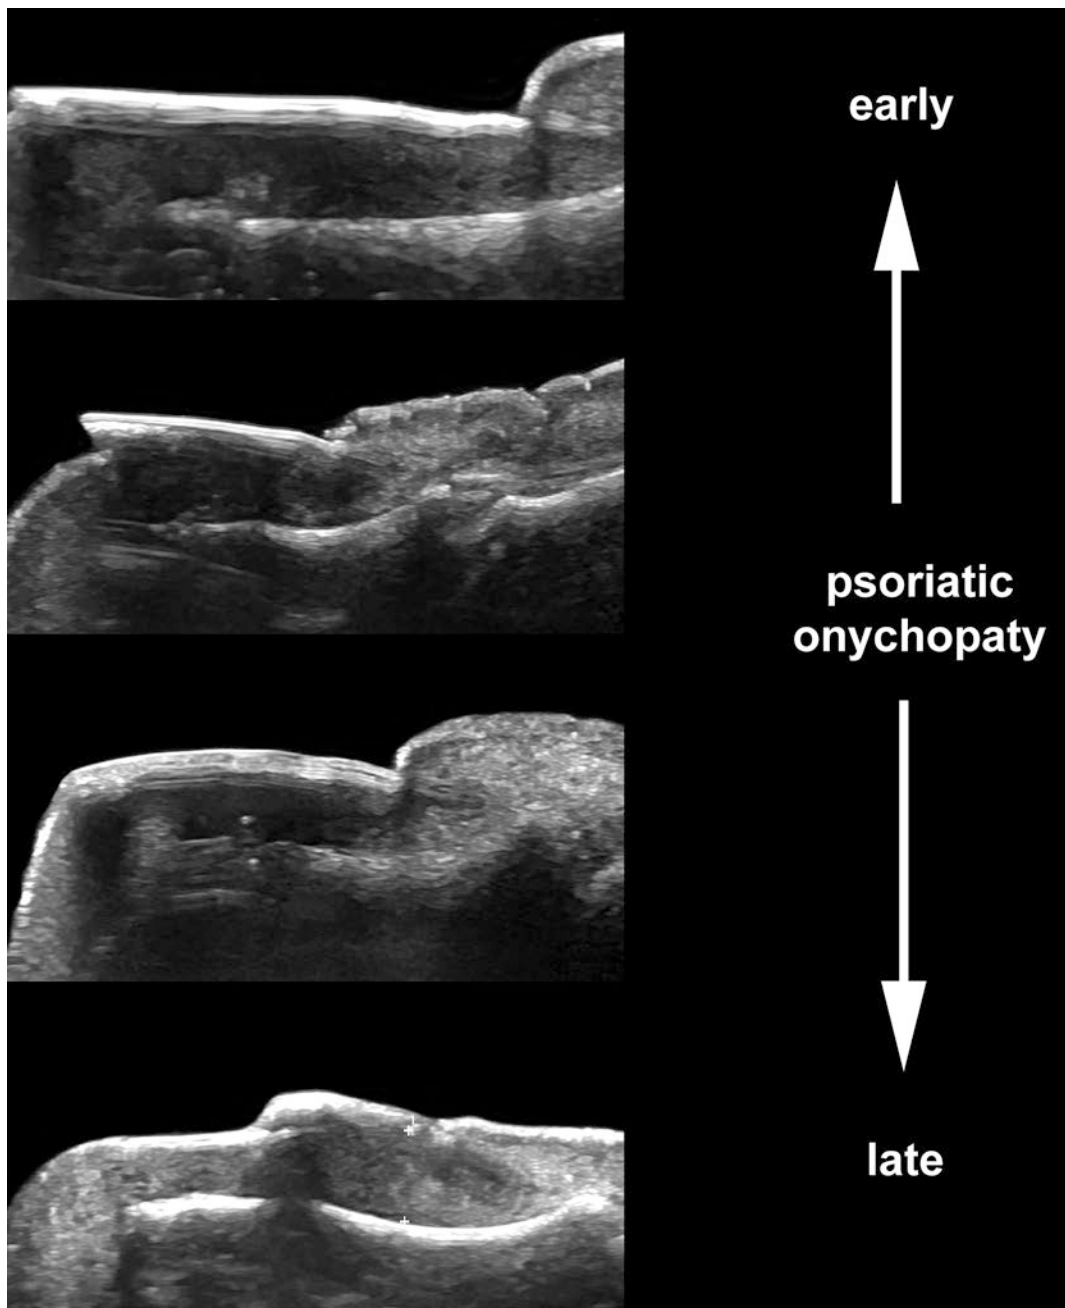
Psoriasis. Ultrasound grading of severity in psoriatic onychopathy
